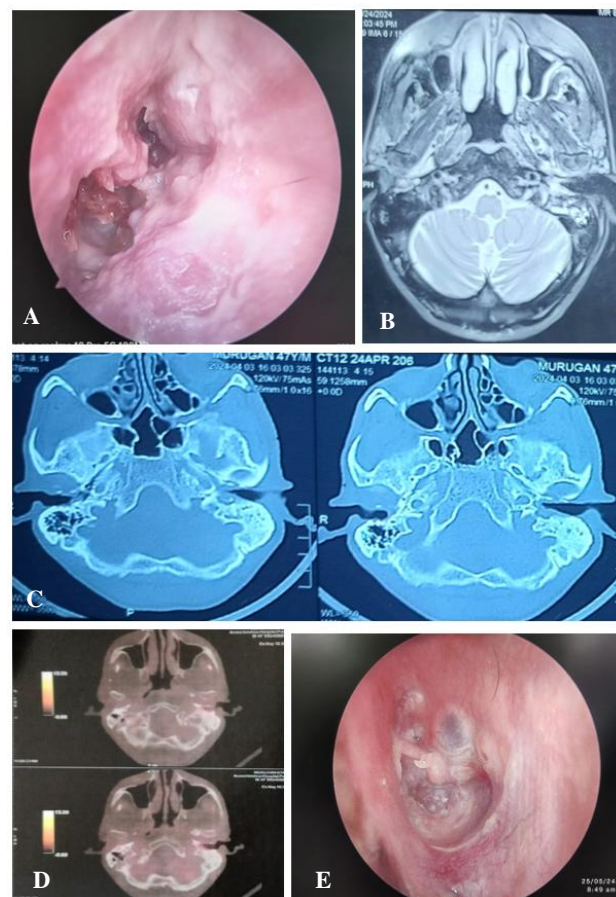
(A-E): Oto-endoscopy (admission), CT temporal bone, MRI skull base, PET-CT and post treatment oto-endoscopy of case 1.
